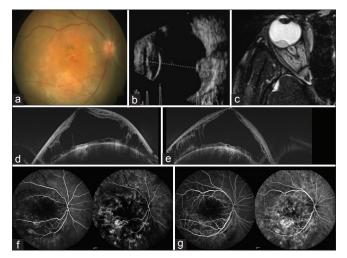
At presentation: fundus photo of the right eye showing circumscribed choroidal hemangioma at the posterior pole with subretinal fluid (a). B-scan ultrasound showing solitary tumor with high surface and moderate-to-high internal reflectivity (b). Magnetic resonance imaging scan showing the tumor that is isointense on T2-weighted image (c). Vertical and horizontal optical coherence tomography scan showing retinoschisis with subretinal fluid (d and e). Simultaneous fundus fluorescein angiography (FFA) and indocyanine green angiography (ICGA) reveals stippled hyperfluorescence in the early phase and increased hyperfluorescene in late phase corresponding to the choroidal hemangioma (f and g)
